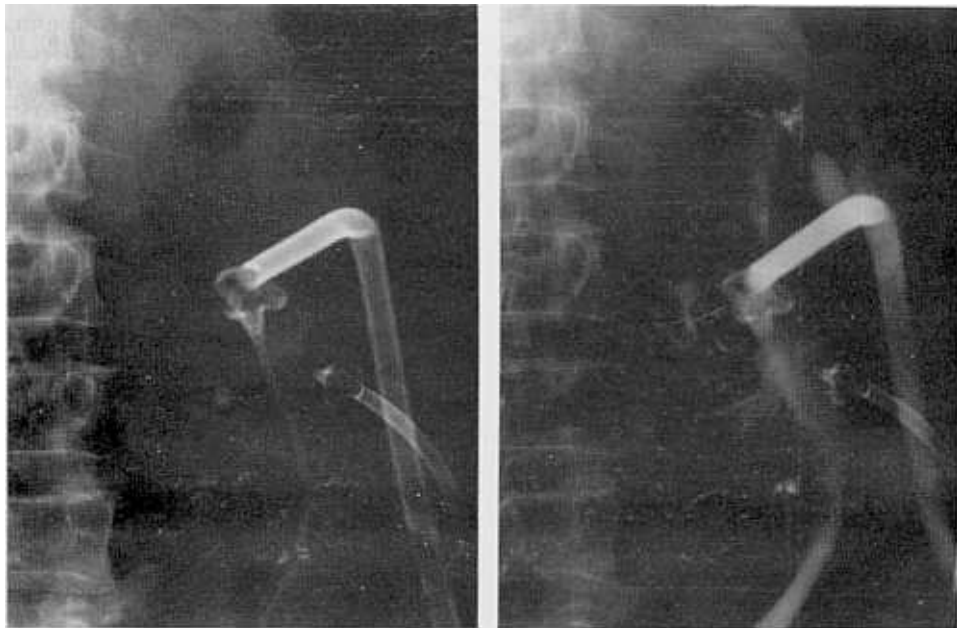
Plain abdominal radiograph following second session shows complete removal of the stone fragments. Second nephrostomy access route was created in order to remove residual stones. Note 14F Malecot nephrostomy catheter. Repeat nephrostogram shows collecting system patency. There is no evidence of extravasation, obstruction or clot retention. The nephrostomy catheters were removed 24 hours later.
